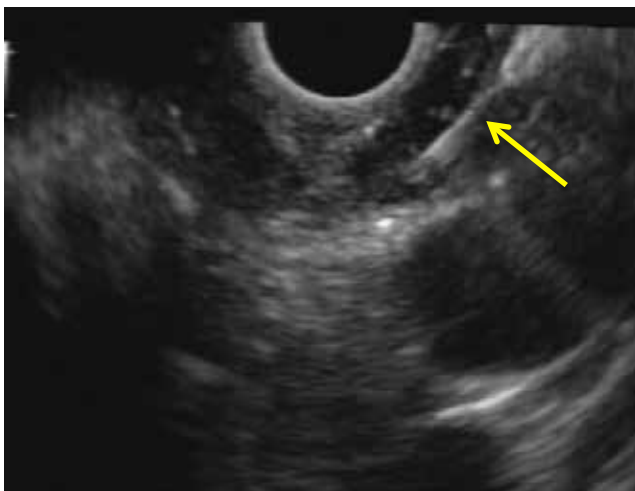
Endoscopic ultrasound-guided fine-needle aspiration. Yellow arrow indicates needle.
